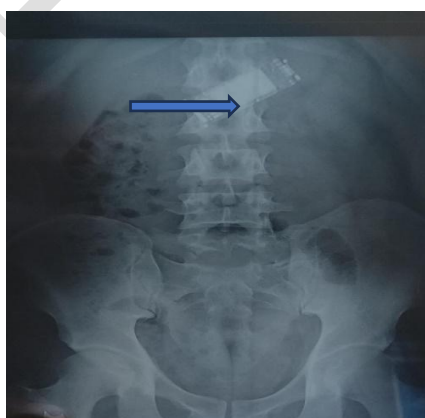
Erect XRay abdomen showing foreign body in stomach.
